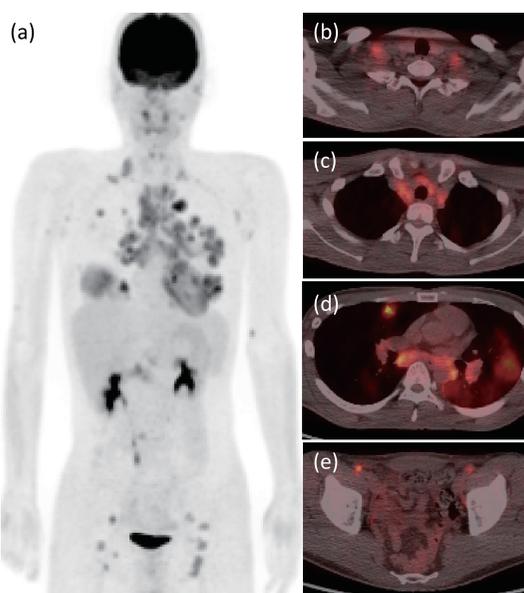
The FDG-PET findings in sarcoidosis.
